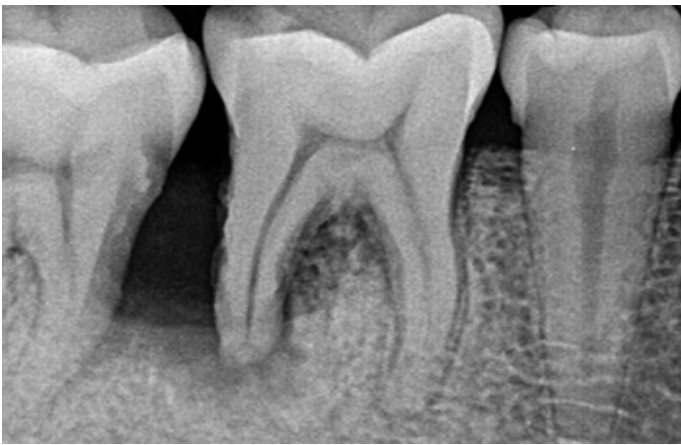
Preop radiograph case 2
